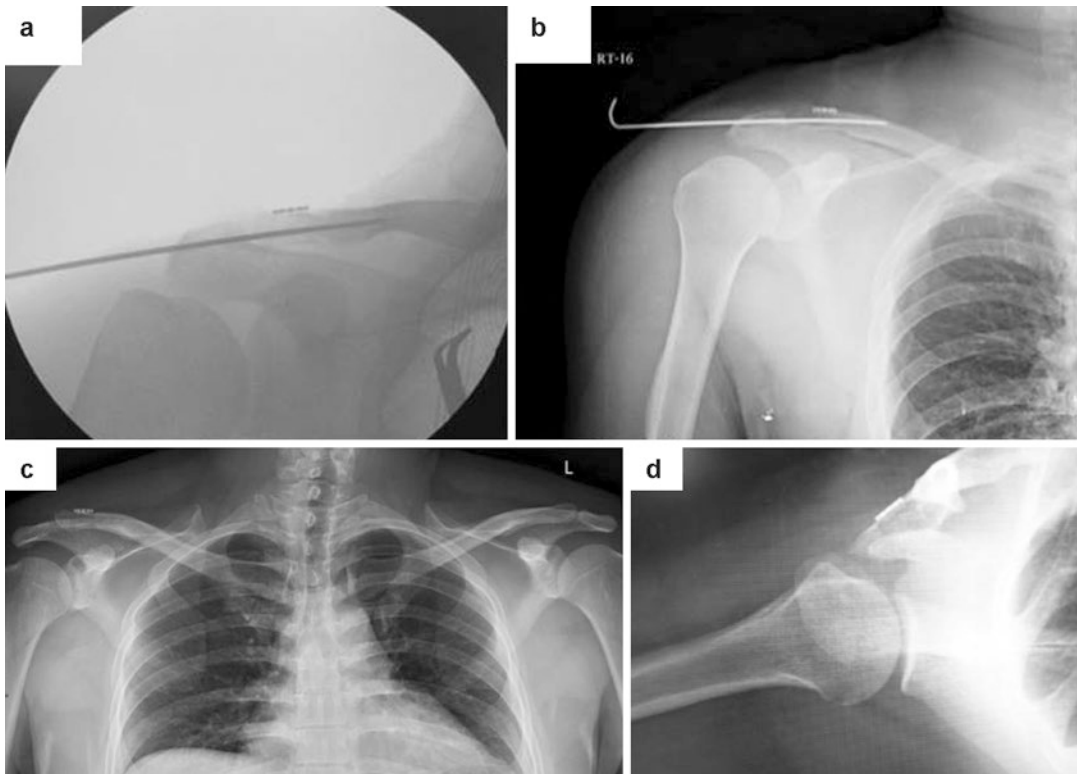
(a) Intraoperative C-arm view. (b) Immediate post-operative anteroposterior radiographic view of the patient showing AC joint reduction-fixation. (c) Six
